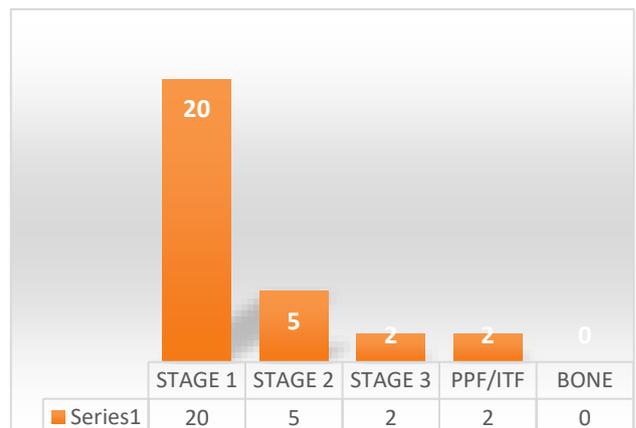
Extend of disease in initial MRI.
